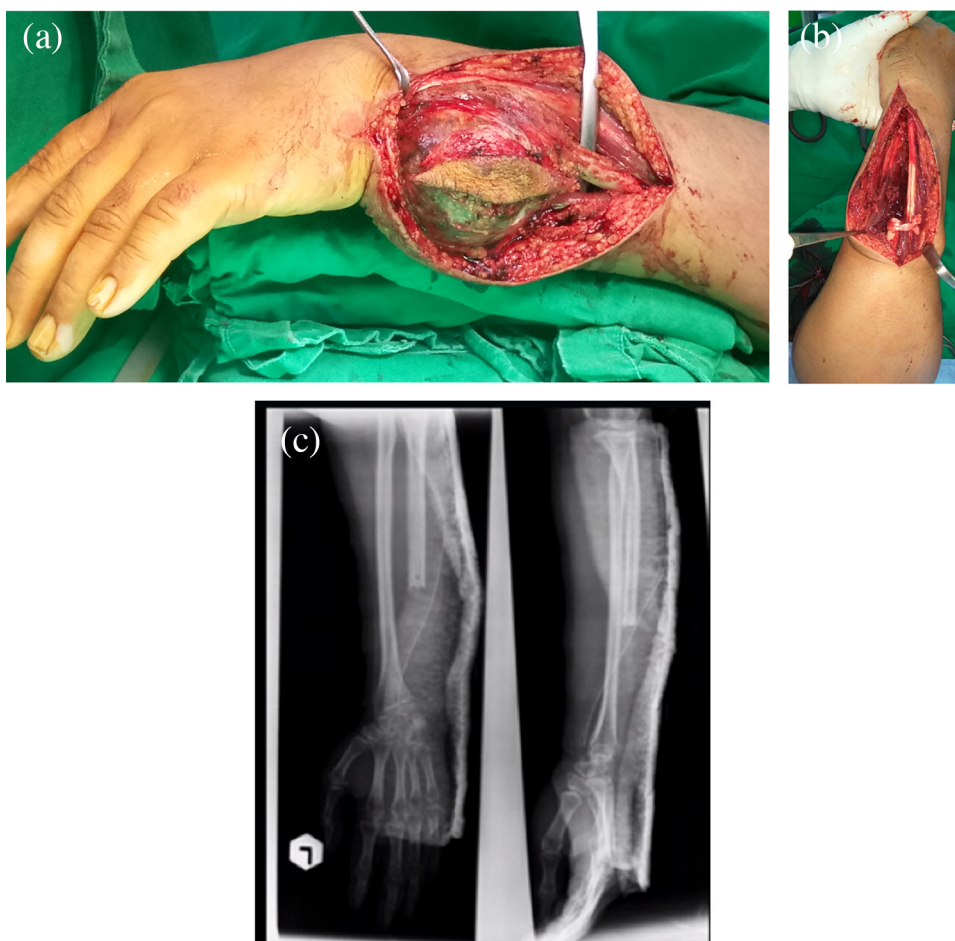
a) Operative photographs showing a large tumor originating from the left ulna (case 1). b) Stabilization ulnar stump using ECU tenodesis technique (case 1). c) AP & lateral radiograph of left lower arm postoperative (case 1).
